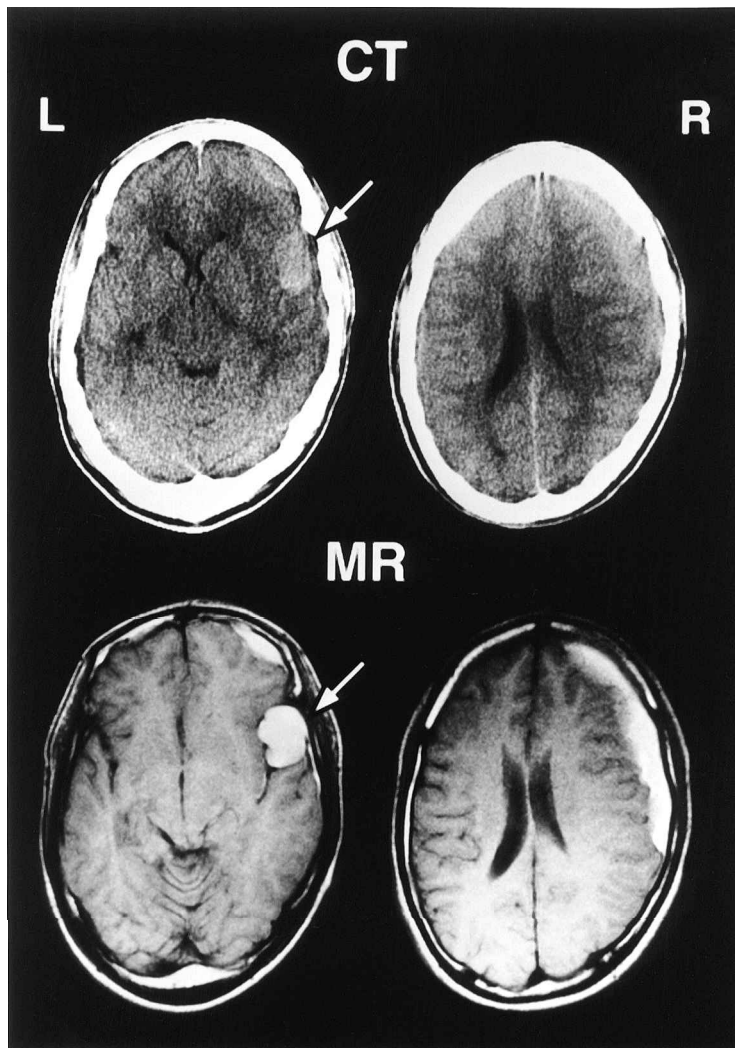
Patient 3. Upper: CT scans showing a high density subdural hematoma in the right frontal region and a high density round mass lesion in the right sylvian fissure (arrow). Lower: MR images revealing the presence of blood in the arachnoid cyst in the right sylvian fissure (arrow).
